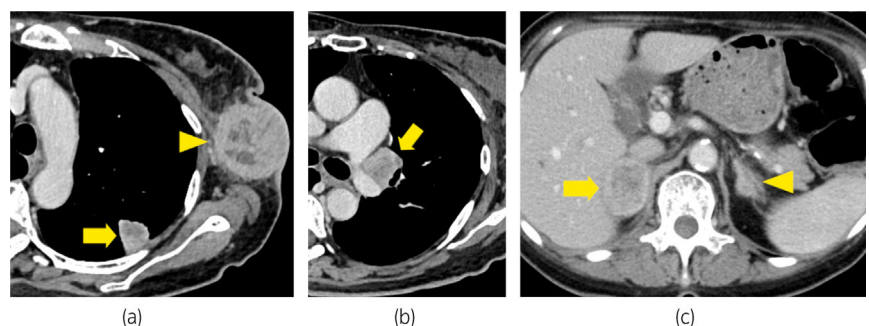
CT showed a left axillary tumor (arrowhead) and a left lung tumor (arrow) (a), left mediastinal lymph node swelling (arrow) (b), right adrenal tumor (arrow), and left adrenal tumor (arrowhead) (c).
